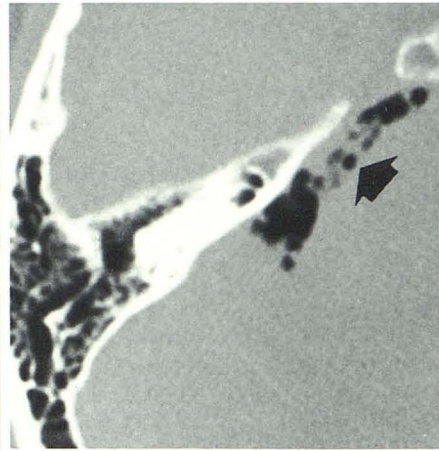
Gas CT cisternography showing network-like structure (arrow) in right cerebellopontine angle.
